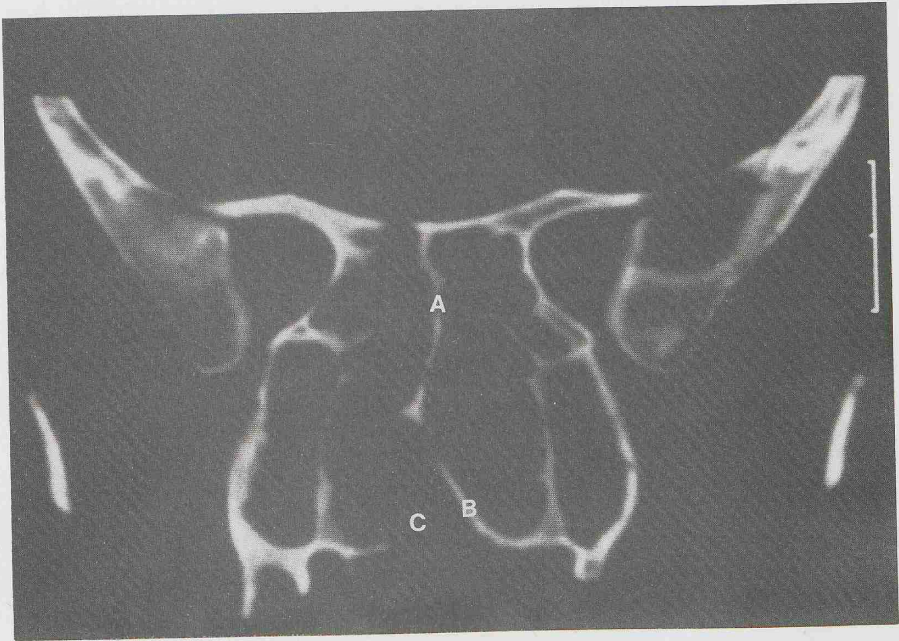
Adult skull with unilateral right-sided cleft of alveolus and palate. CT-scan, frontal plane.
